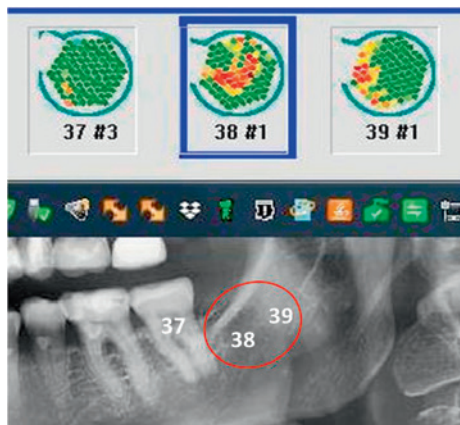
Example of the color-coding scheme associated with attenuation used by TAU-n in area 38. In the upper panel, the measurement of jaw areas 37 to 38/39 (*i.e.*, the retromolar area) is presented. TAU-n displays different degrees of mineralization, as highlighted by the various color patterns of 91 individual sensor fields that correspond to each jawbone area. Green indicates hard and dense structures that correspond to a higher degree of mineralization in spongyal jawbone or cortical bone; it also denotes teeth, dental crowns or implants. Yellow indicates diminished bone density and also corresponds to the nerve canal in the lower jaw. Red indicates severely diminished bone density with a low degree of mineralization, corresponding to BMDJ/FDOJ areas. BMDJ/FDOJ = bone-marrow defects of the jaw/fatty-degenerative osteolysis/osteonecrosis of the jaw; TAU-n = new through-transmission alveolar ultrasonography.
